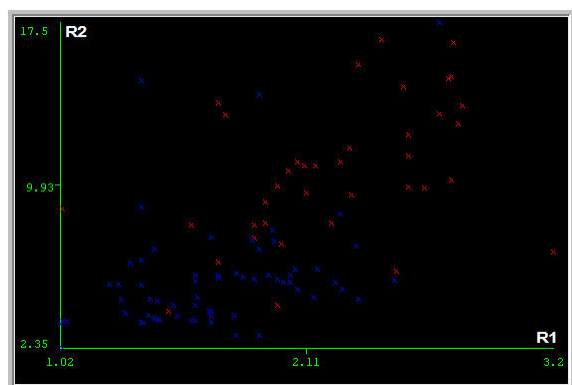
Ultrasound analysis: R1 vs R2 and R2 vs R3.
